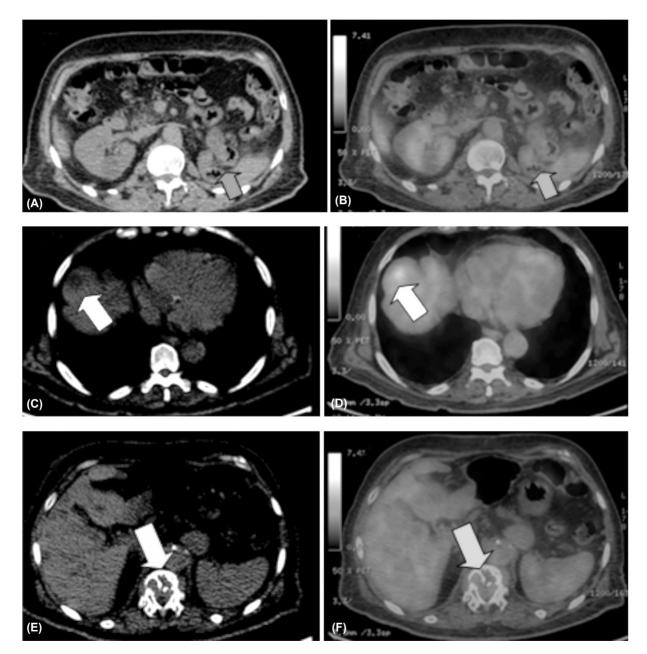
Axial CT and fused PET-CT images for a 65 year male patient with history of treated left renal cell carcinoma by left nephrectomy followed by chemotherapy.
